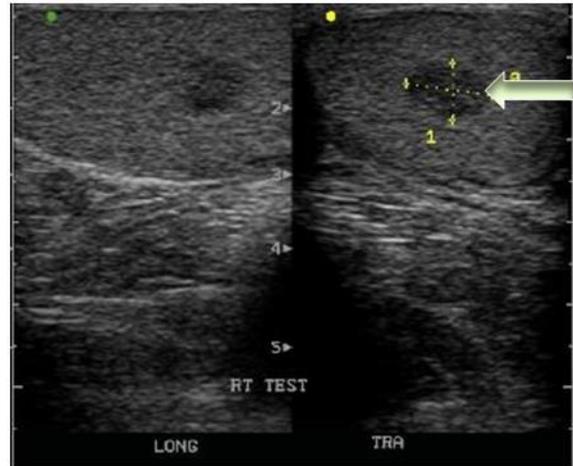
a: Focal area of hypochoic lesion (High Frequency Ultrasound Image)
